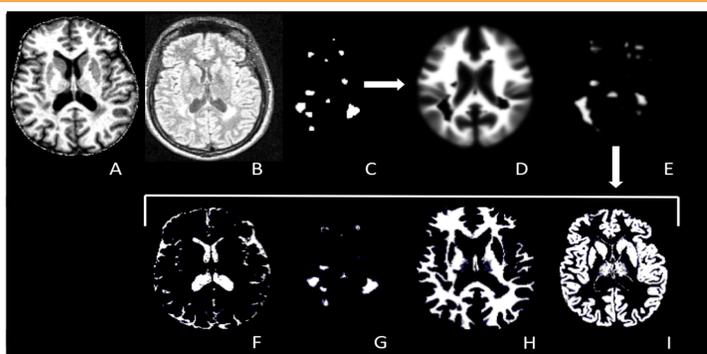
Example of USwL application on a MS patient (data from the GIGA-CRC). (A, B) MT and FLAIR-weighted MR images; (C) approximate binary lesion mask; (D, E) updated WM and lesion prior probability maps; (F-I) a *a posteriori* probability maps for CSF, lesion, WM and GM tissue classes.
